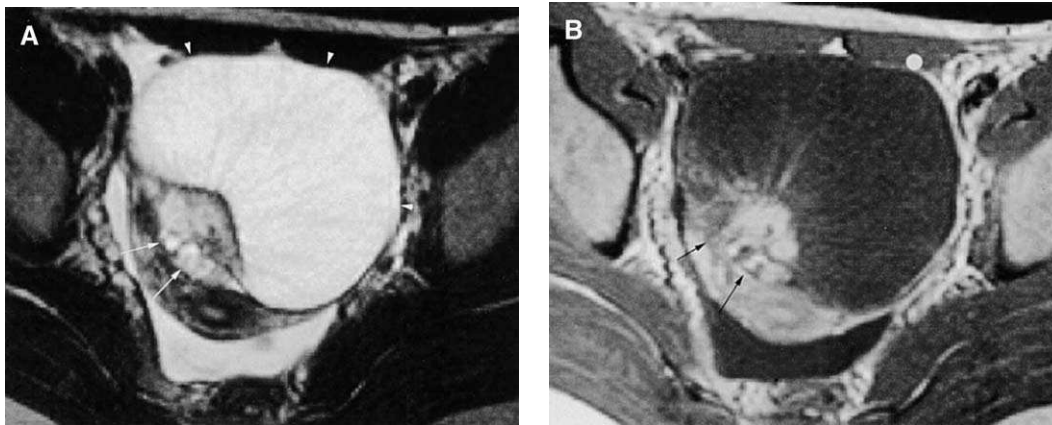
Massive ovarian edema. (A) T2-weighted image shows the ovary (arrowheads), which is extremely swollen but still keeps the shape of a fava bean, and the ovarian hilum (arrows). Within the ovary, fine radiations from the hilum can be seen. (B) Postcontrast image shows strong enhancement of the ovarian hilum (arrows) and a lack of enhancement of the entire ovary, except for weak enhancement in the radiations.
